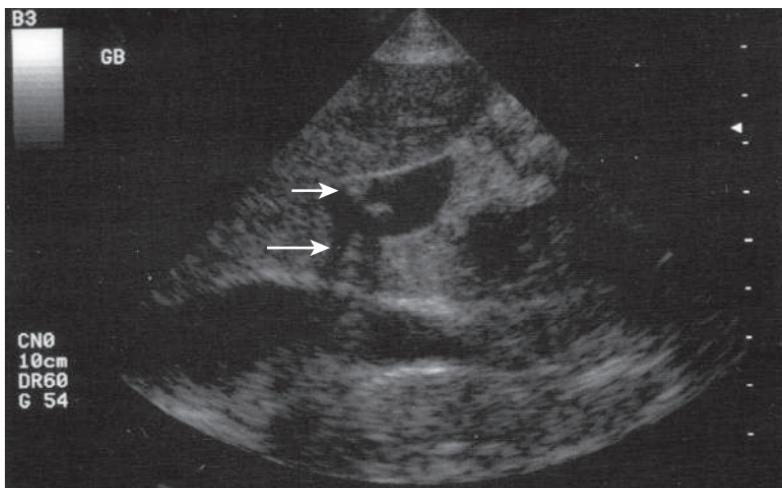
Ultrasound image reveals an anechoic gallbladder containing two echogenic stones, which are creating acoustic shadowing inferiorly. The *short arrow* is pointed to the gallstones within the gallbladder, and the *long arrow* points to the shadowing effect of the stones.
